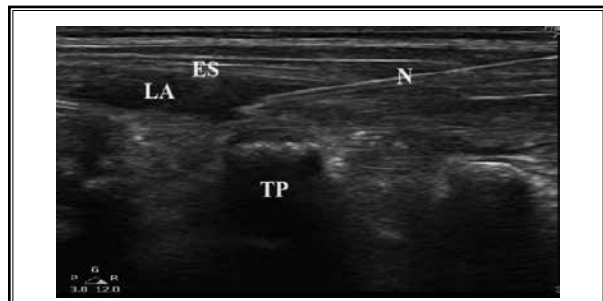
Ultrasound-guided erector spinae plane block.*
